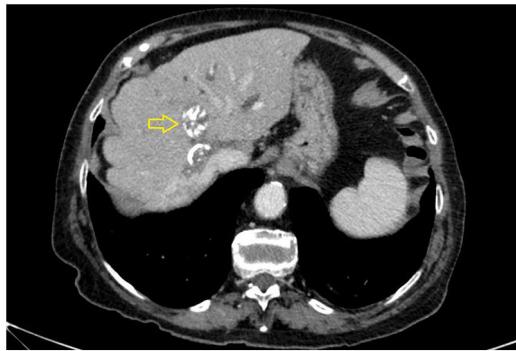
Computed tomography image showing 2 round calcified lesions suggestive of hydatid cysts (yellow arrow).
